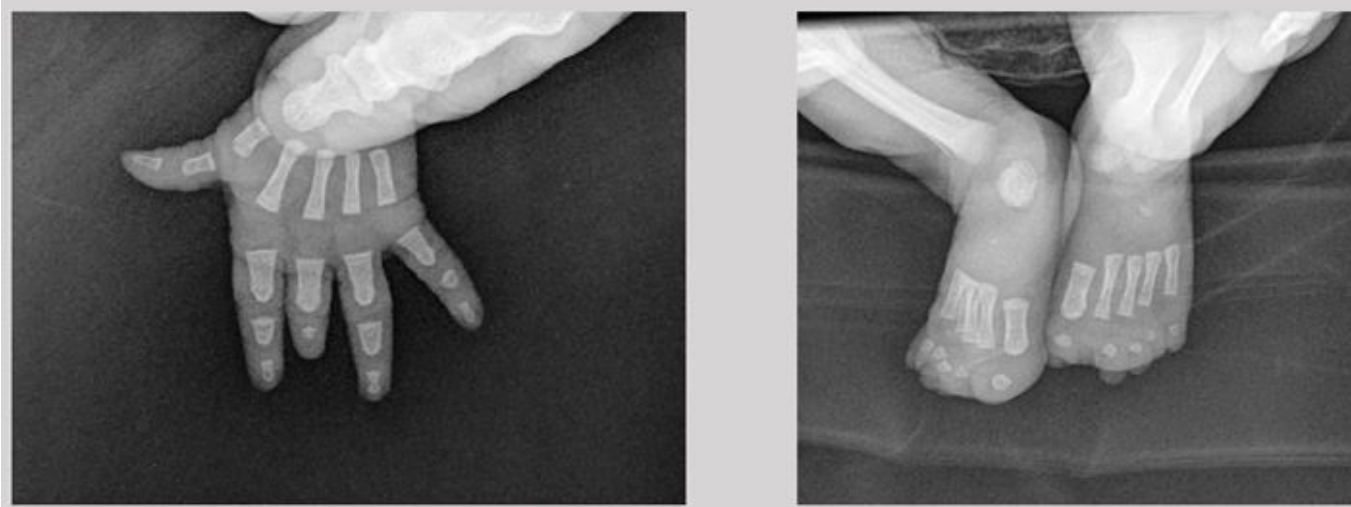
X-ray at 6 months postpartum demonstrating agenesia of the distal phalanx of the 3<sup>rd</sup> finger of the left hand and agenesia of the phalanges of all toes.
